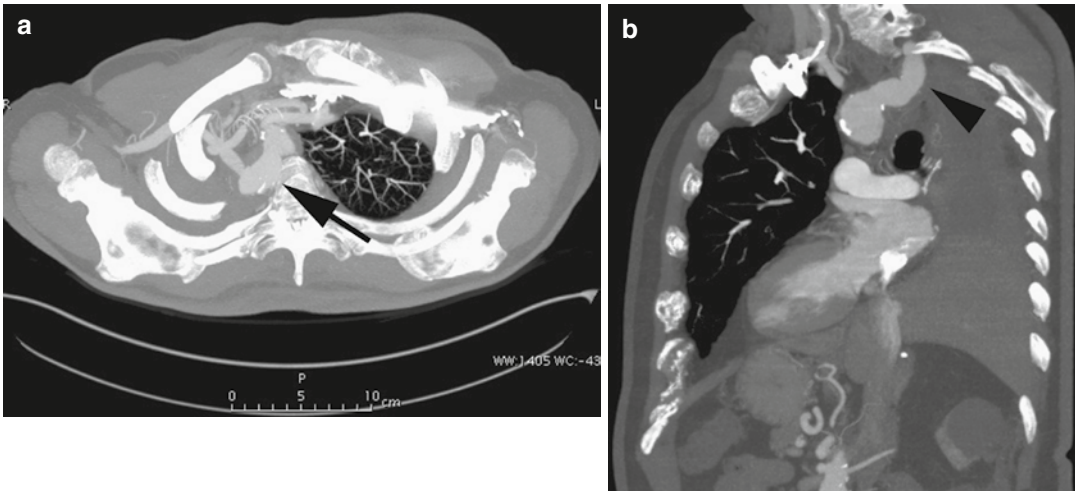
Axial (a) and sagittal oblique (b) CT MIP images in a patient post-right pneumonectomy, with retroesophageal right aberrant subclavian artery with proximal
